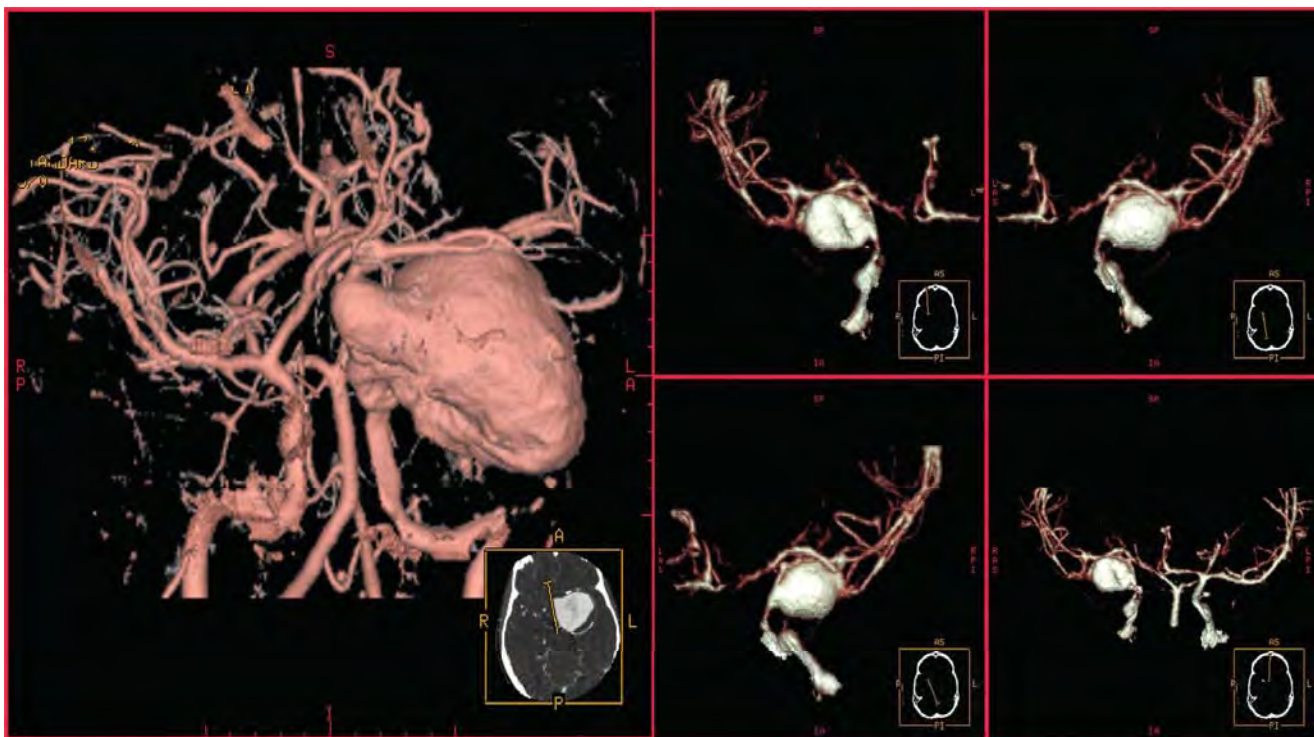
Computed tomography angiography—giant paraclinoid aneurysm left
